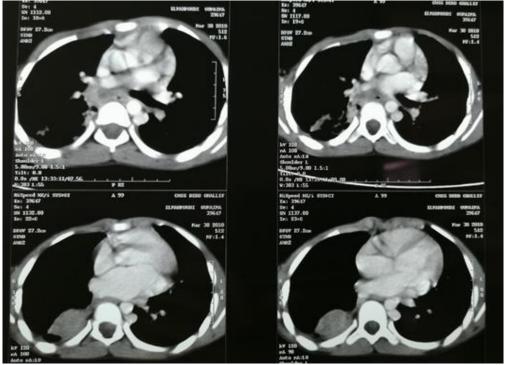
Chest CT scan of 2010
